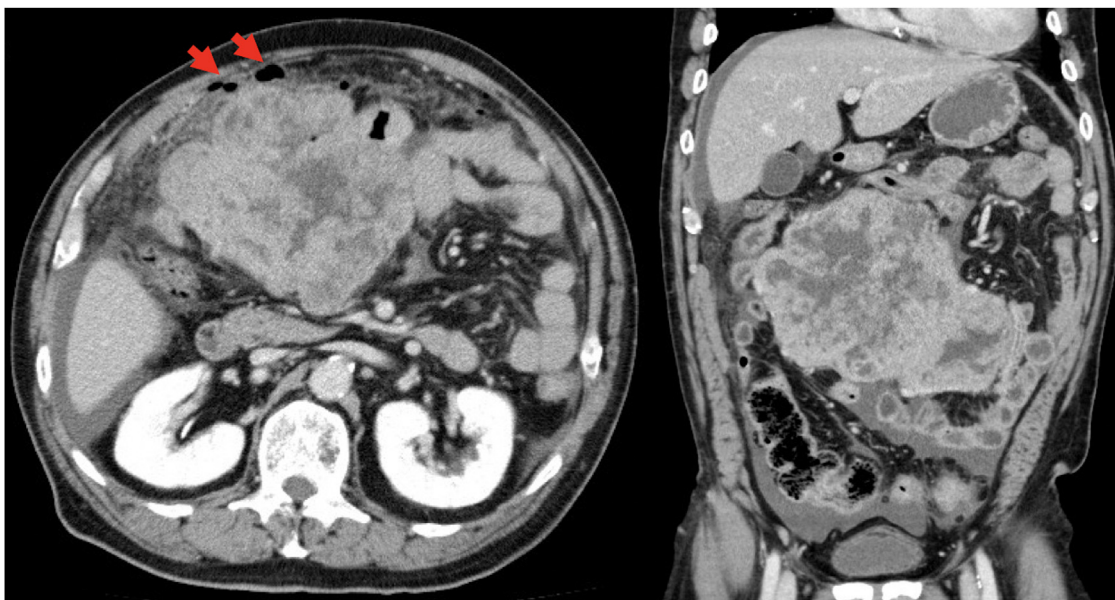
Contrast-enhanced abdominal computed tomography showed free air (the red arrow), amount of ascites and a massive tumor which was 15 × 11 × 20 cm in size and with mixed by hypodensity and hyperdensity.
